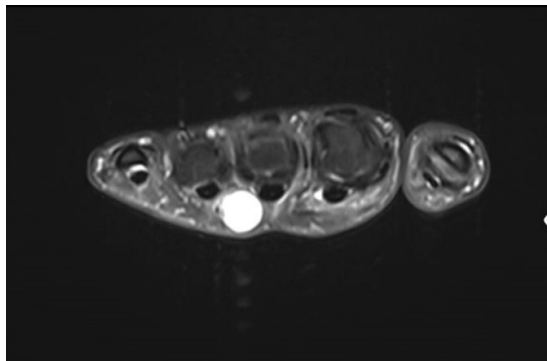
Axial MR image of digital artery aneurysm
